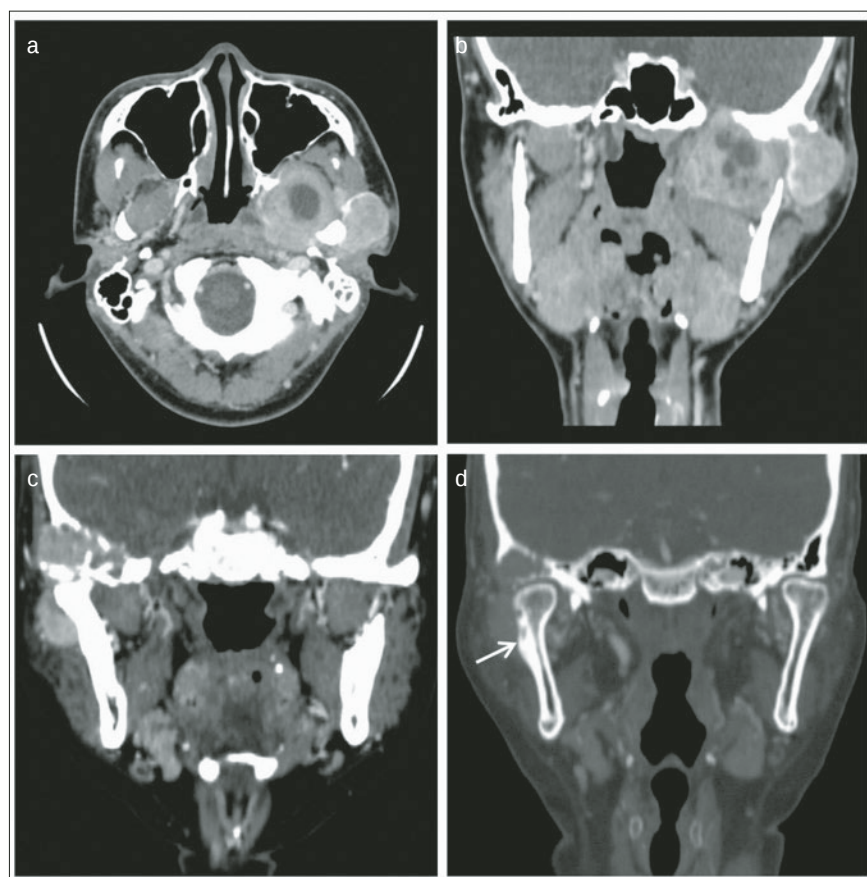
to d CT findings of D-TSGCTs in the TMJ. An ill-defined periarticular mass with marginal enhancement in a left TMJ (a and b). Destruction of the skull base in a right TMJ, and periosteal reaction was seen in the bone window (arrow) (c and d).
